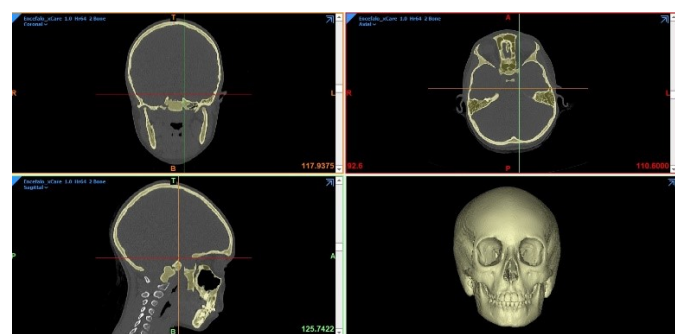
3D reconstruction of the skull from axial, coronal and sagittal views from the CT examination.
